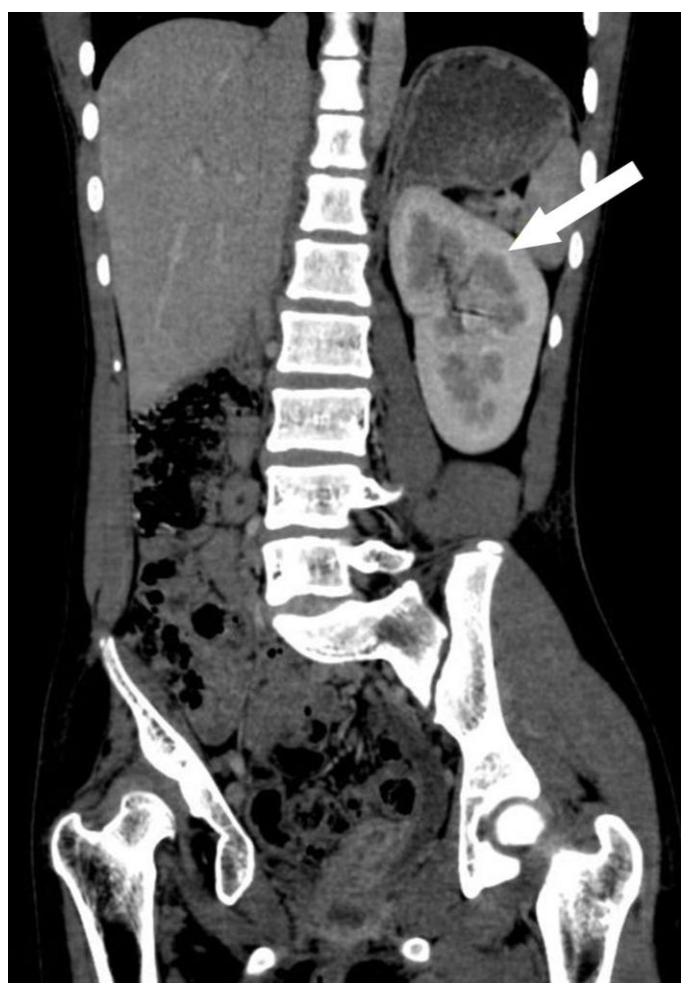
(left): 12 year old female with urinary bladder and right renal agenesis. Contrast enhanced CT abdomen in portal venous phase and multiplanar coronal reformat shows orthotopic mildly enlarged left kidney (arrow) showing normal enhancement of parenchyma. Odd positioning is due to dysplastic right hip. Protocol: Philips Brilliance 64 slice CT 200 mAs, 120 kV, 3 mm slice thickness, 45 ml Omnipaque.
